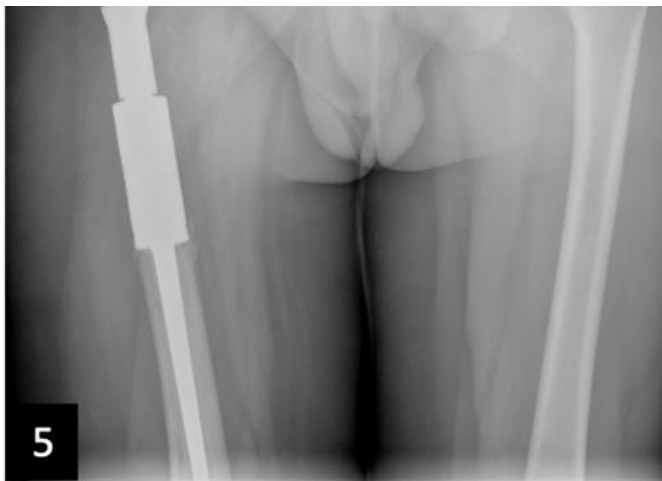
Postoperative pelvis x-ray. Replacement of the proximal femur and acetabulum with a megaprosthesis.
